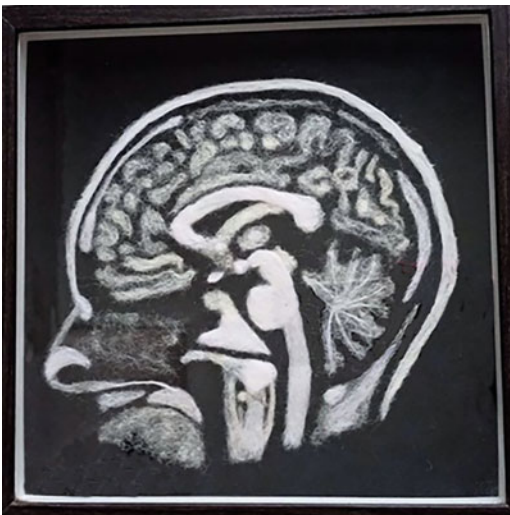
A felted reproduction of an MRI on black velvet. Original picture supplied by Dr. Amanda Meyer (photo Janet Philp)
